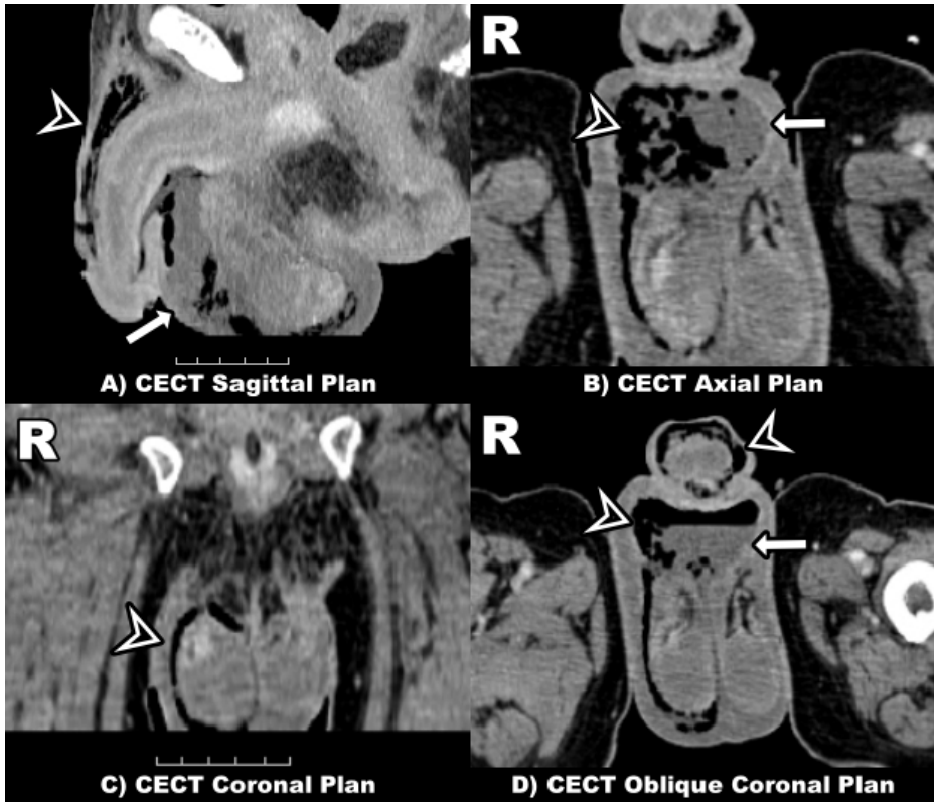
A 59-year-old male patient presented with severe scrotal pain, swelling, and redness extending to the perineal and penile region in addition to abdominal pain. The patient had a history of colon cancer with metastases to the liver and bones. Contrast enhancement CT was applied to the patient. A-D) Subcutaneous air densities (arrowheads) were observed in both intrascrotal areas and around the penis, more prominently in the right intrascrotal area. In addition, there was an increase in leveling fluid (white arrows) containing air densities in the right intrascrotal space (This figure was obtained from Assoc. Prof. Dr. Leyla KARACA's archive with her permission. Department of Radiology, Medical Faculty, İnönü University, Malatya, Turkey)
